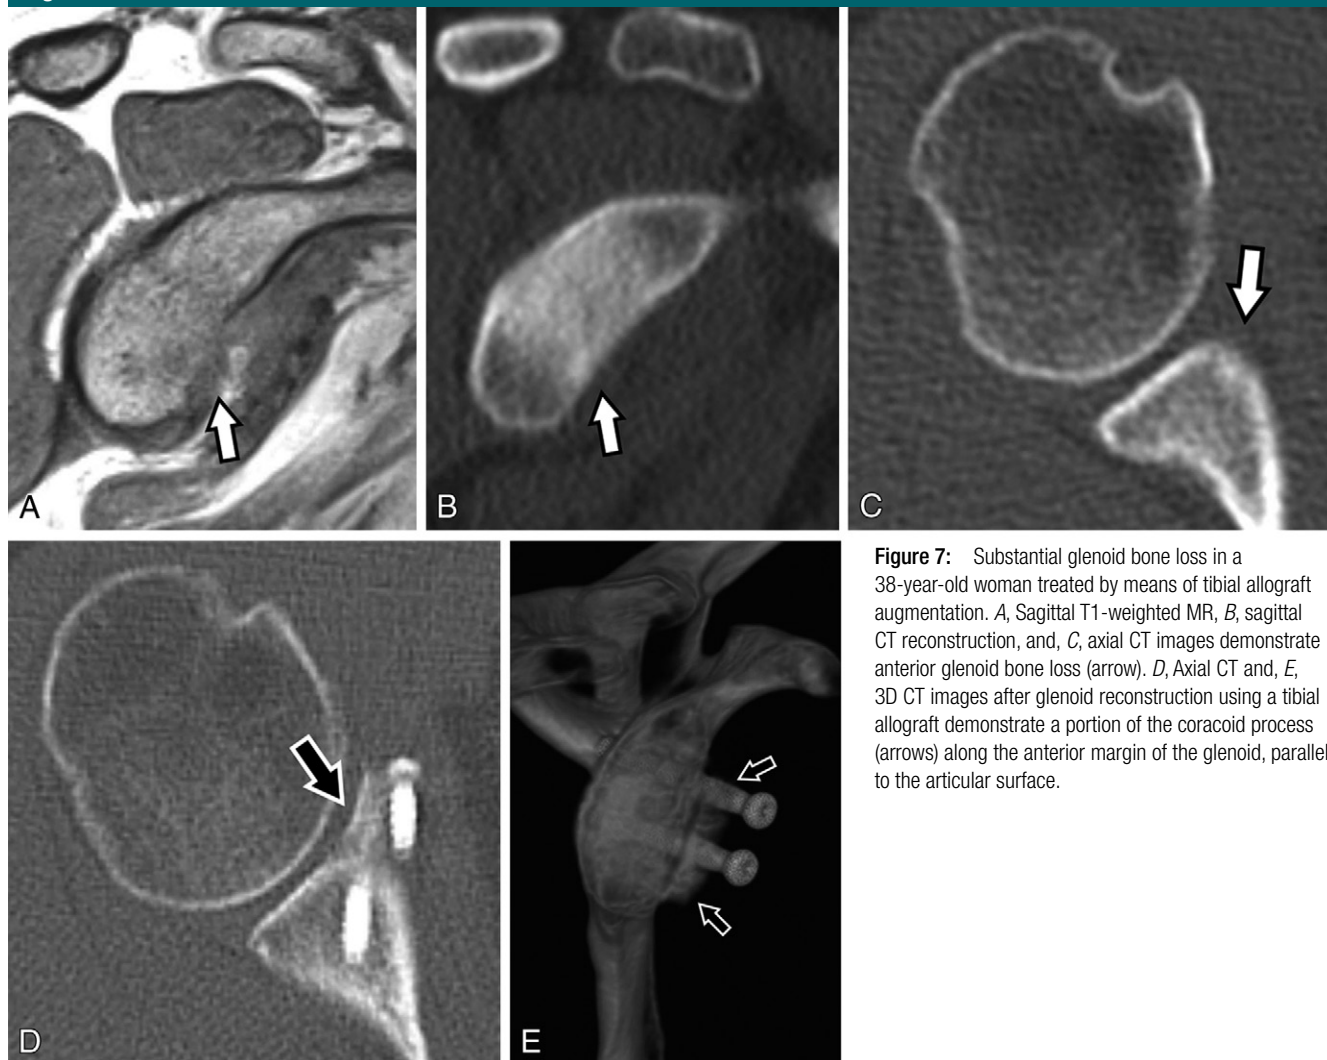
Substantial glenoid bone loss in a 38-year-old woman treated by means of tibial allograft augmentation. *A*, Sagittal T1-weighted MR, *B*, sagittal CT reconstruction, and, *C*, axial CT images demonstrate anterior glenoid bone loss (arrow). *D*, Axial CT and, *E*, 3D CT images after glenoid reconstruction using a tibial allograft demonstrate a portion of the coracoid process (arrows) along the anterior margin of the glenoid, parallel to the articular surface.
